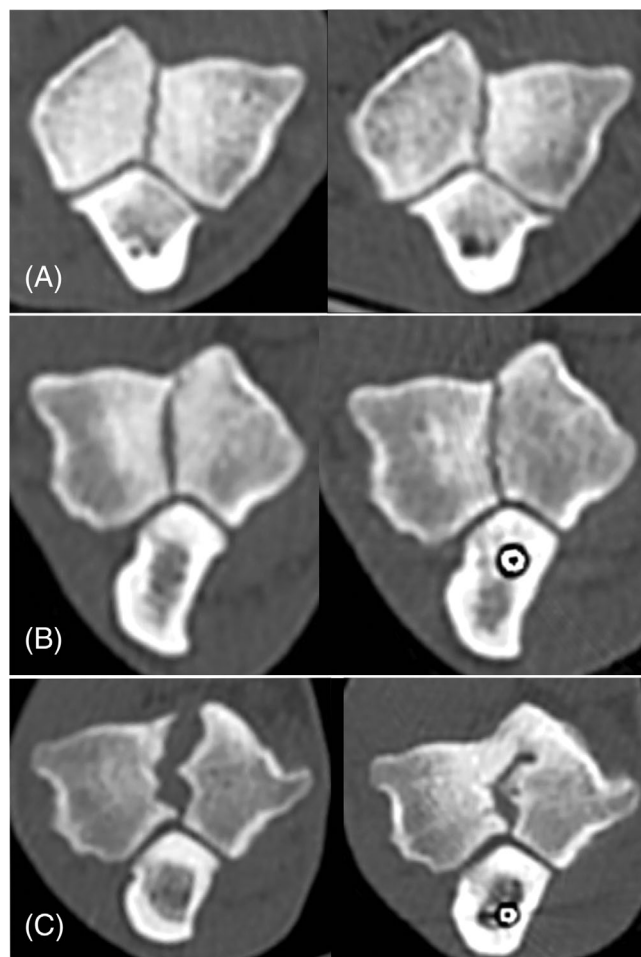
Examples of progressive healing of the fissure achieved after performing an oblique proximal ulnar osteotomy (PUO) (left column: preoperative computed tomographic (CT) images; right column: latest follow-up CT images). (A) A 2-year-old cocker spaniel (A2: 24-month follow-up). (B) A 4-year-old english springer spaniel (ESS) (B2: 10-month follow-up). (C) An 8-month-old ESS (C2: 18-month follow-up).
